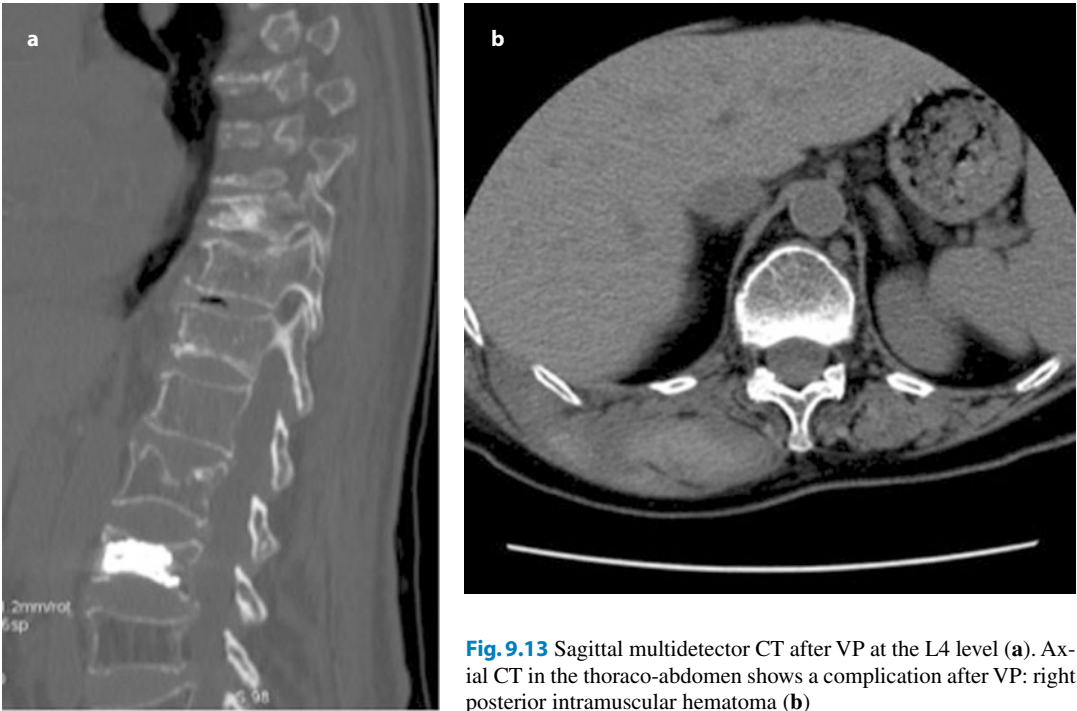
Sagittal multidetector CT after VP at the L4 level (a). Axial CT in the thoraco-abdomen shows a complication after VP: right posterior intramuscular hematoma (b)
